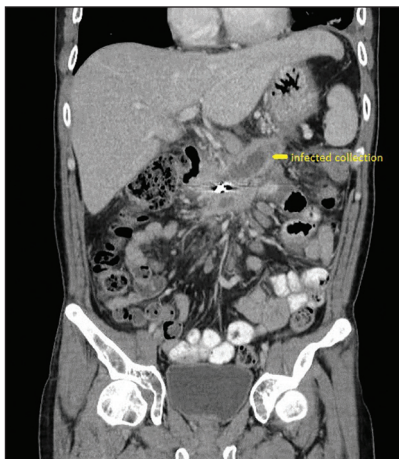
Computed tomography image of infected walled off pancreatic necrosis
